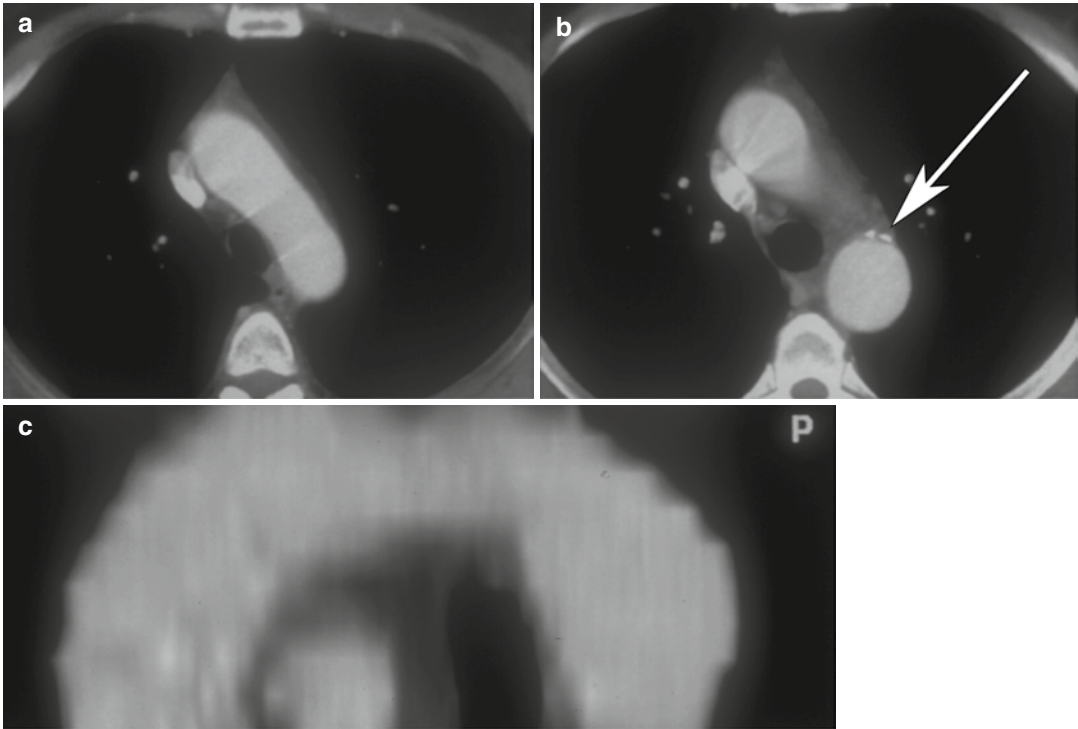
Axial CT images (a, b) and sagittal-oblique MPR image (c) of aortic spindle, which is a normal mild dilation of the most proximal descending thoracic aorta.
